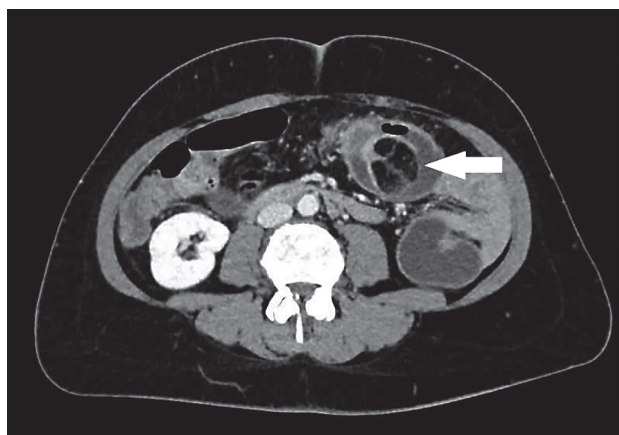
Abdominal hydro-computed tomography, venous phase, axial view. The lipomatous mass lesion aborally to the intussusception showed as a well-defined, fat-density lesion.
